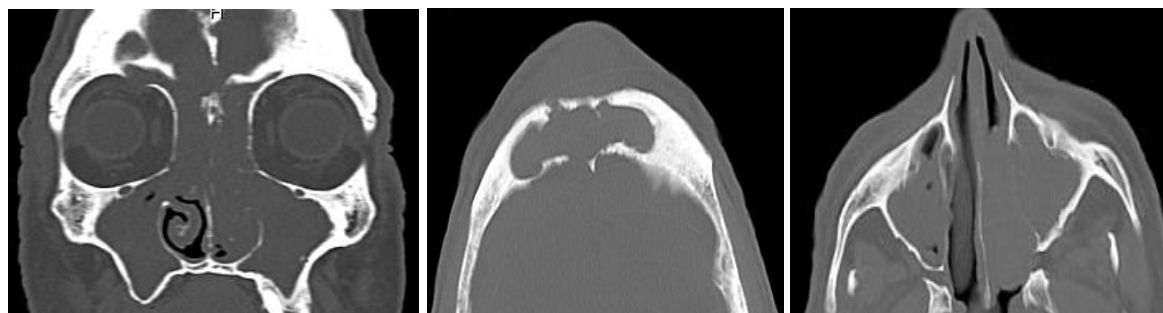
Computed tomography of the facial craniomass with contrast, axial section. A). Erosion of the internal and external table of the frontal sinus is observed. B). Density of soft tissue occupation of the left nasal cavity with heterogeneous characteristics that gives the impression of capturing contrast
